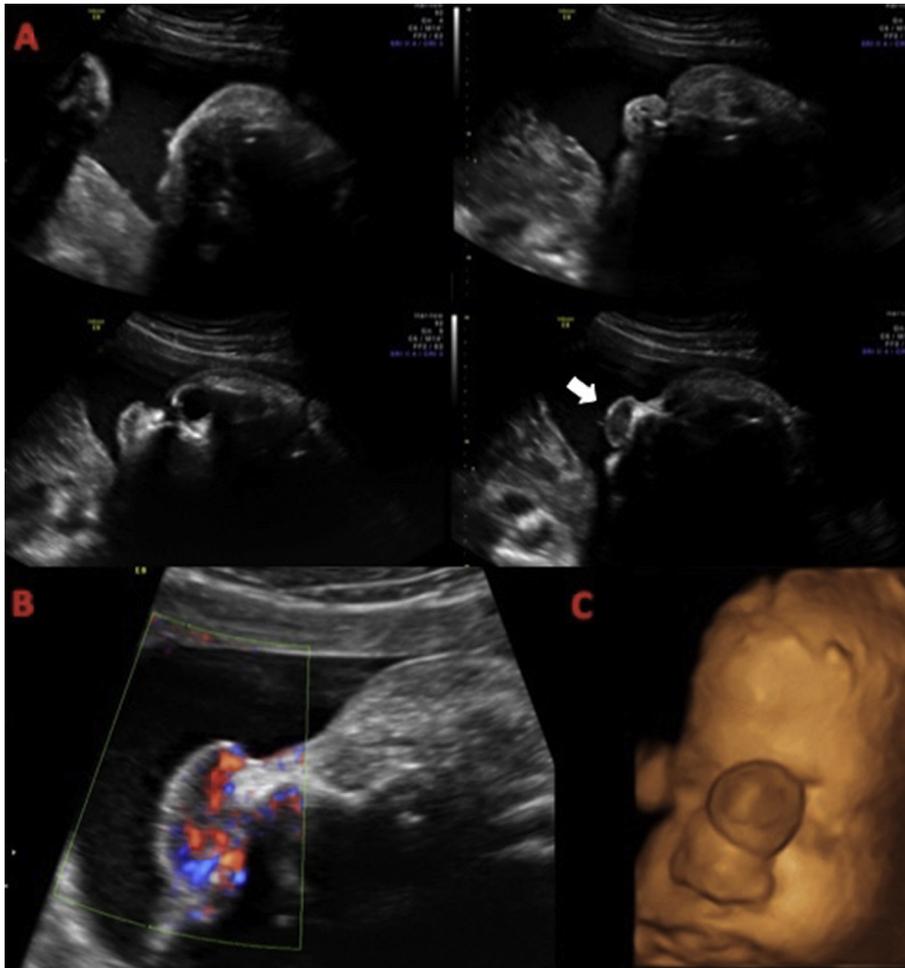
The prenatal ultrasound findings, A) B-mode, arrow showing the tumor B) Doppler flow C) 3D ultrasound.
